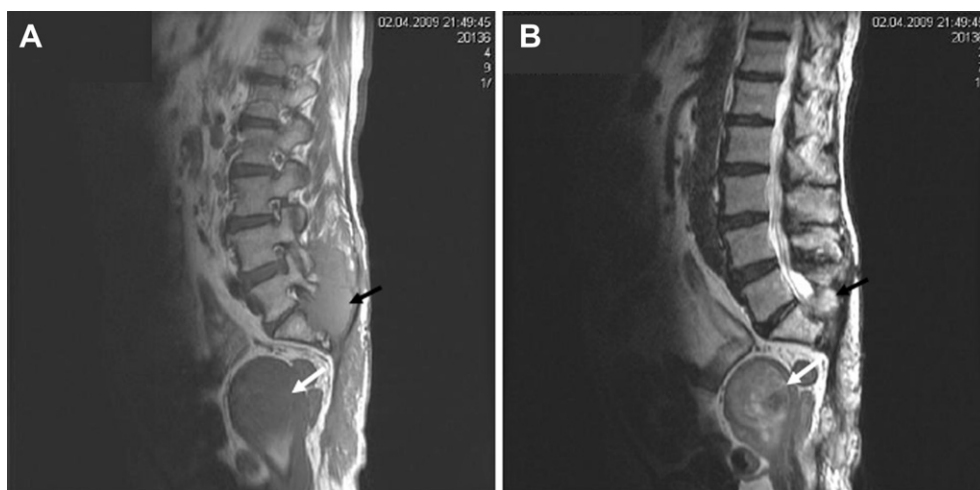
(A) T1-weighted sagittal image; a hypointense recurrent sacral chordoma (black arrow) and a heterogeneous hypointense mass filling the endometrial cavity of the uterus (white arrows). (B) T2-weighted sagittal image; the relatively hyperintense uterine mass (white arrows). Hypointense areas within the endocavitary mass denote hemorrhage. The sacral chordoma (black arrow) is also seen as a relatively hyperintense mass partially filling the spinal canal and abutting the filum terminale.
